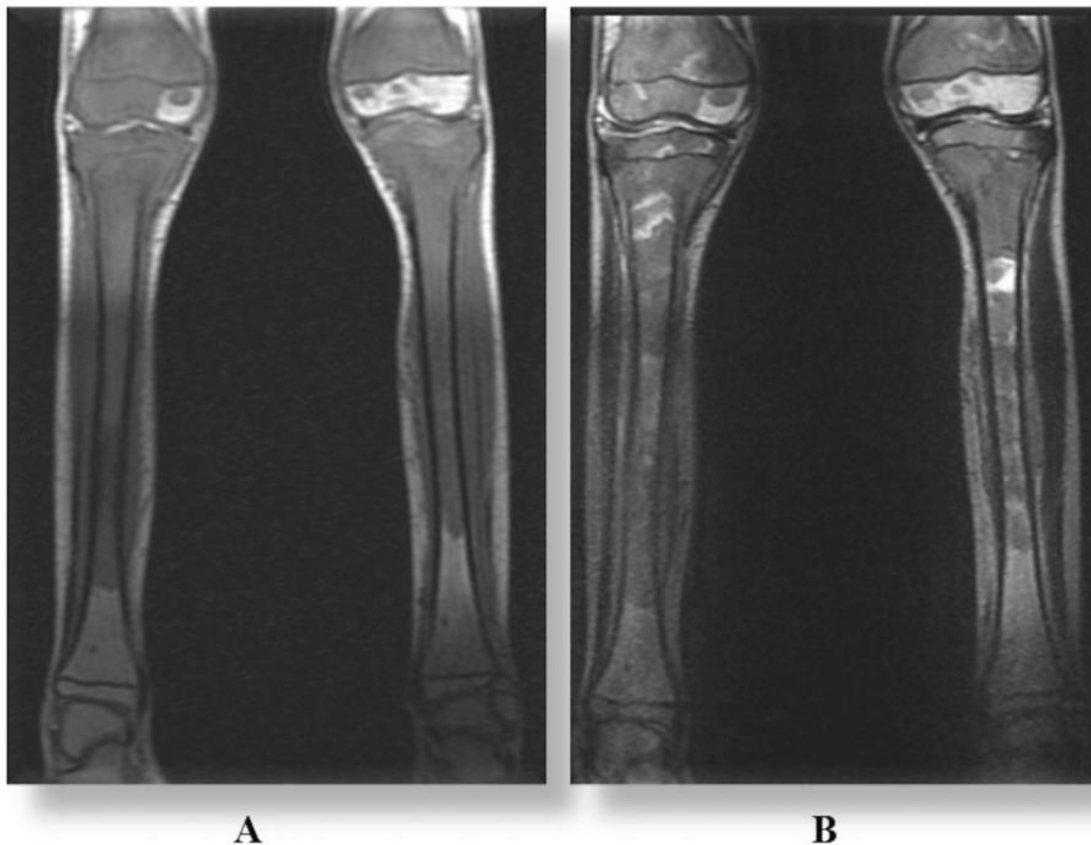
MRI of both legs in coronal view, T1-weighted sequence (A) and T2-weighted sequence (B).
